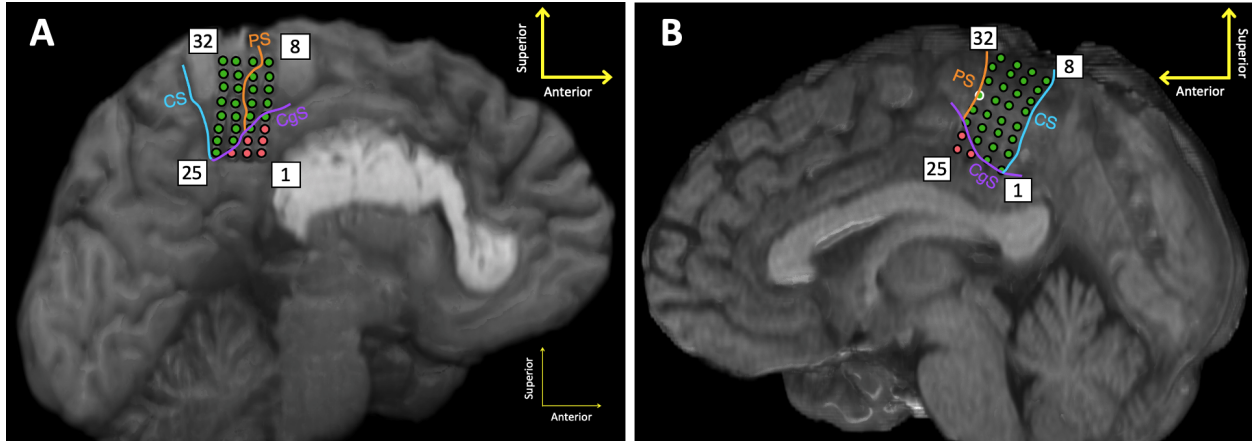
Location of the interhemispheric ECoG grid electrodes, determined by MRI, for SJ1 (A) and SJ2 (B). The approximate location of anatomical features are shown as colored lines. CS: Central Sulcus, PS: Precentral Sulcus, and CgS: Cingulate Sulcus. Green electrodes are located in M1 and pre-motor cortex areas, whereas red electrodes are located outside the motor areas. We only decoded data from the green electrodes. For SJ2, data from electrode 29 (outlined in white) was not available during the constant-speed task.
